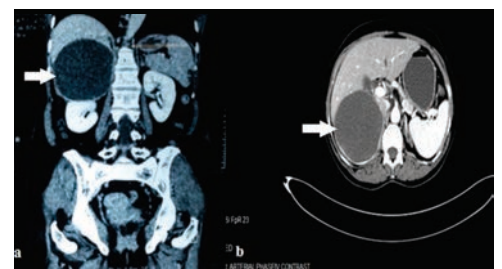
(a) Contrast enhanced computed tomography, solid arrow showing the adrenal cyst in axial cut (b) Contrast enhanced computed tomography, solid arrow showing the adrenal cyst in coronal cut
